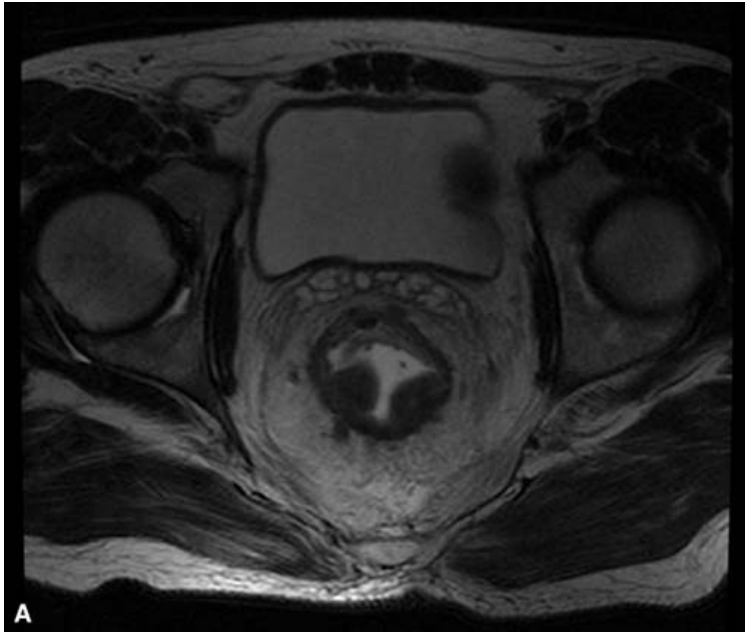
Magnetic resonance imaging for rectal cancer. Imaging is essential to determine the invasion of the tumor into the rectal wall. A. Axial view. B. Sagittal view.
